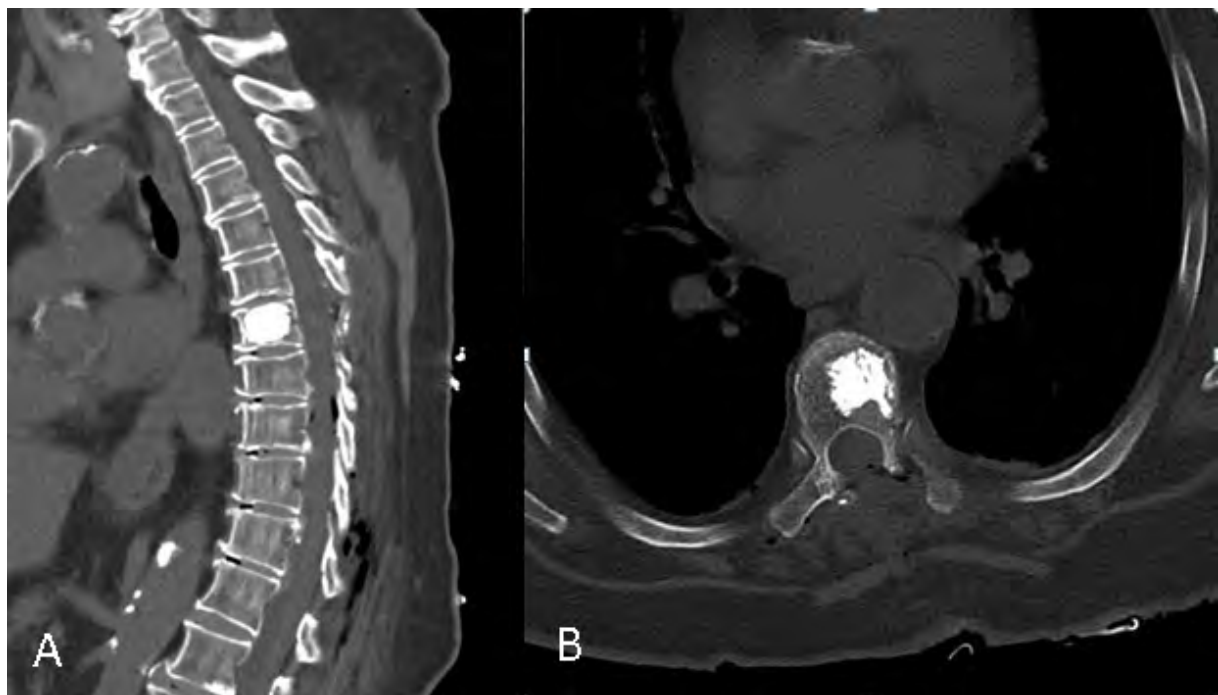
(A) sagittal and (B) axial early postoperative control thoracic CT showing the mass was totally excised and the polymethylmethacrylate (PMMA) applied to the 7. thoracic vertebra.
